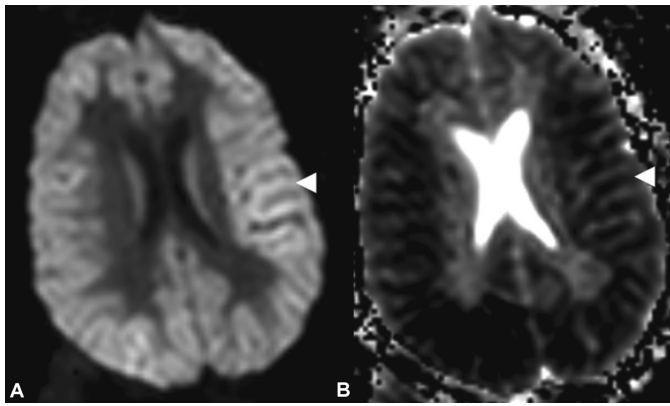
Global anoxic brain injury from asphyxiation. A: This b1000 DWI sequence shows diffuse, symmetric cortical hyperintense signal (*arrowhead*). B: ADC shows corresponding hypointense signal (*arrowhead*).
